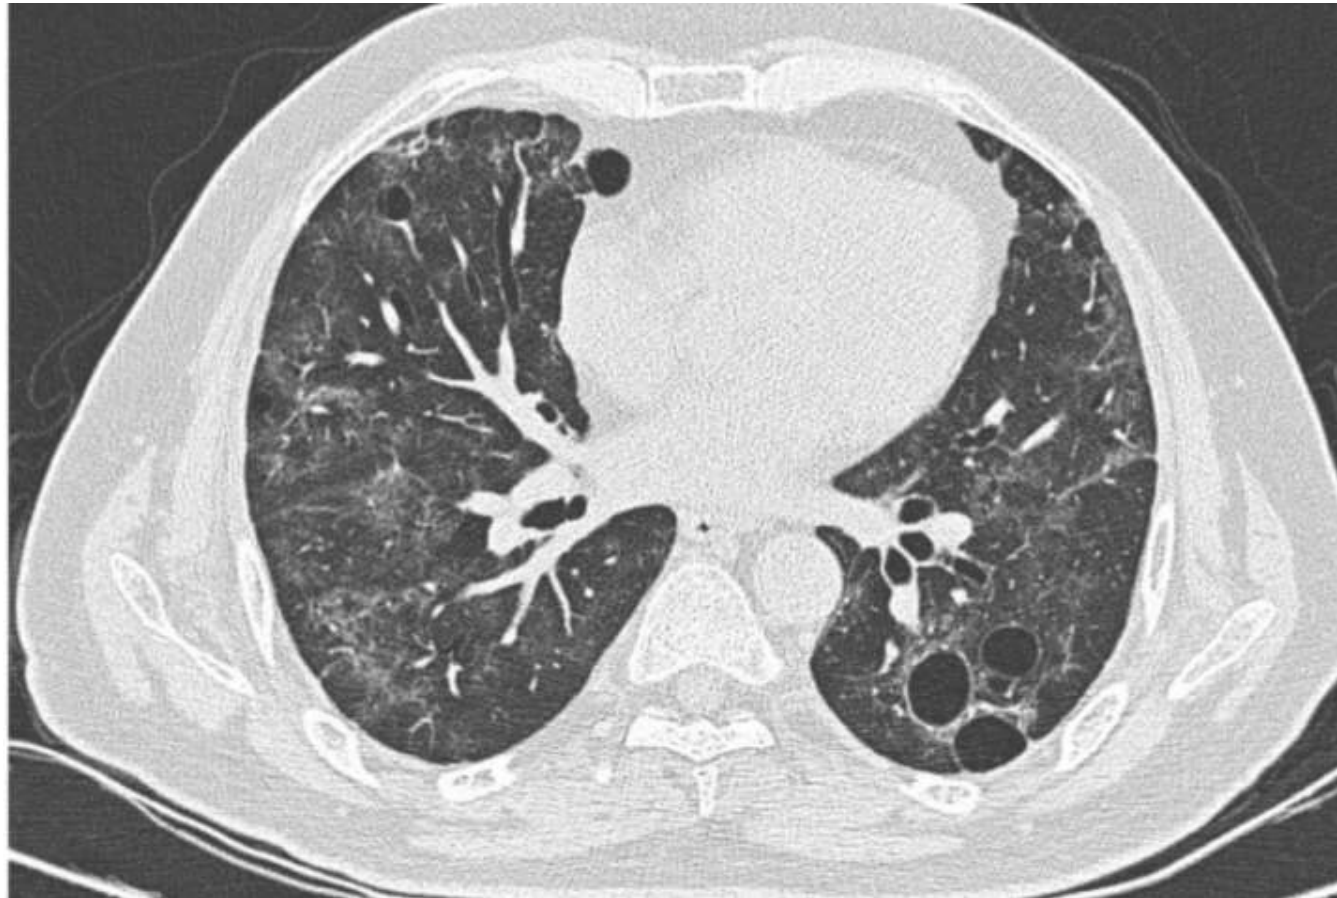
Axial thin-sections unenhanced CT scan show multiple patchy ground glass opacities with underlying reticulation and in left upper lobe a parenchymal alteration central excavation of 22 mm × 24 mm and craniocaudal extension of about 28 mm (arrows).
